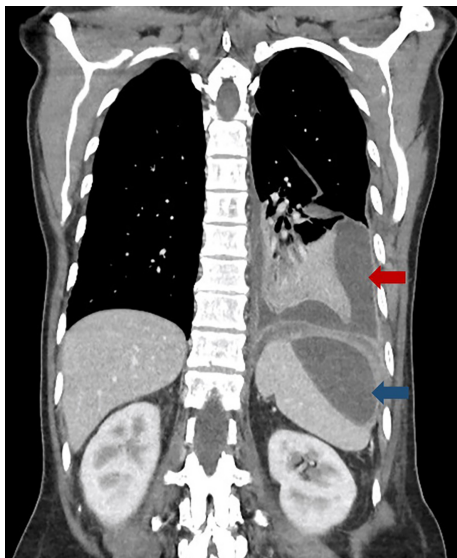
CT image of the chest/abdomen demonstrating a $51 \times 40 \times 49$ mm hypodense lesion with peripheral enhancement consistent with a subcapsular splenic abscess (blue arrow) with subphrenic component and left-sided moderate-volume loculated pleural effusion with peripheral enhancement in keeping with an associated empyema (red arrow).
